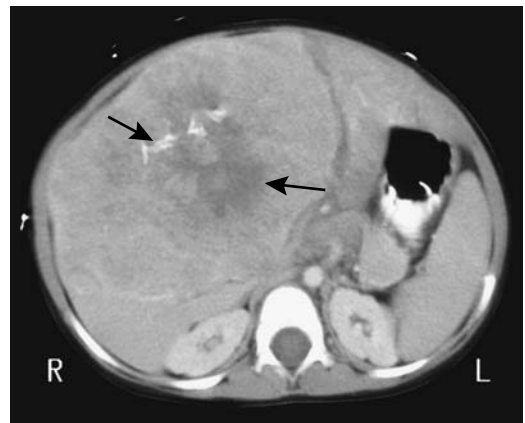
Hepatoblastoma with pulmonary metastases in a 2-year-old girl. The tumor was discovered incidentally. Contrast-enhanced CT reveals a large slightly enhancing tumor (arrows) containing central necrosis and calcifications. (Courtesy of Luann Teschmacher, M.D., University of Rochester.)
